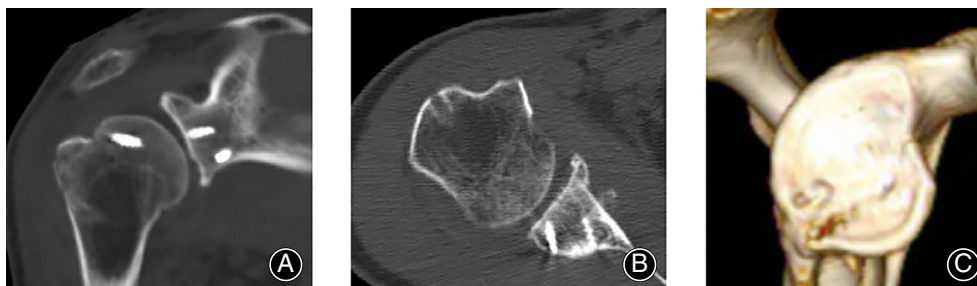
Post-operative CT scans showing the well-reduced fracture fragment. (A) Post-operative coronal 2D CT image showing the well-reduced fracture fragment of greater tuberosity and glenoid. (B) Post-operative axial 2D CT image showing well-maintained reduction of the fracture fragments. (C) Post-operative 3D CT image of en face view showing reduction of the glenoid fracture.
